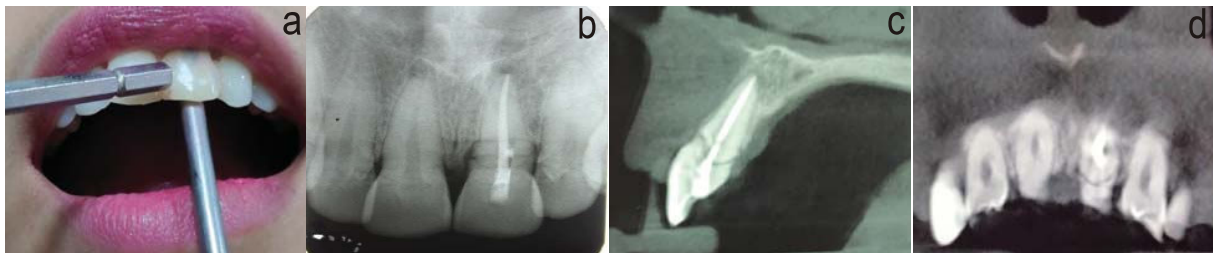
(a) Pre-operative photograph checking mobility, (b) Pre-operative IOPA, (c) CBCT showing sagittal view, (d) CBCT showing axial view.
